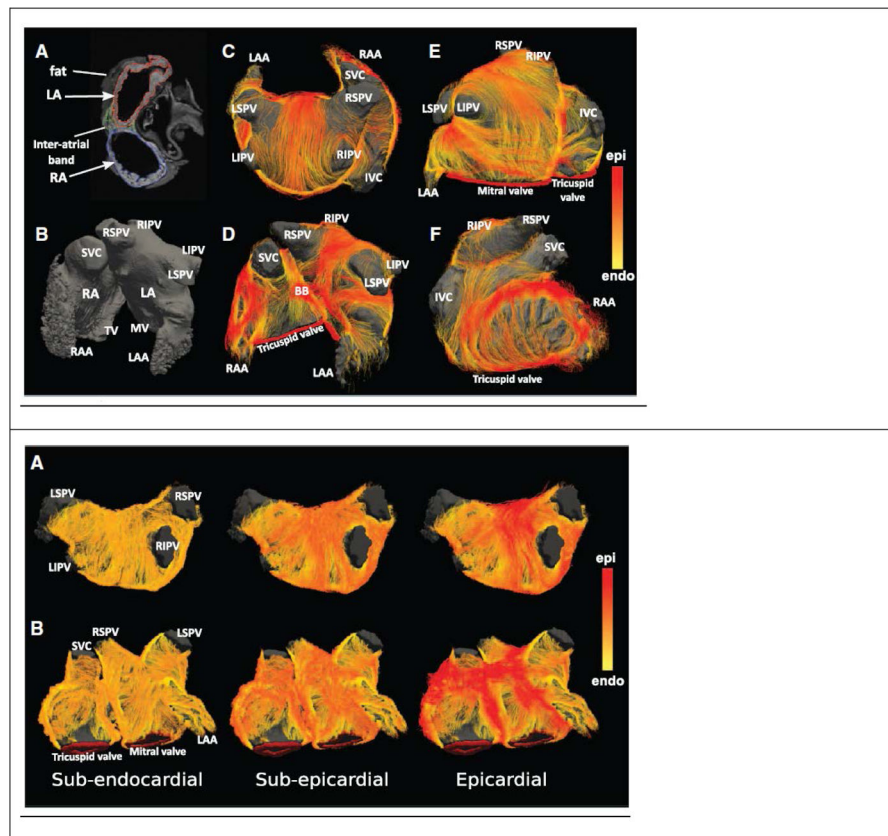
Fiber tractography of normal human atria, obtained from diffusion-weighted MRI imaging of ex-vivo samples. (Top) Atrial geometry. Left column (A, B) shows standard T1-weighted MRI images of the anatomy. Middle column (C, D) External surface view of the fiber tracts. Right column (E, F) anterior view of atrium. (Bottom) Changes in fiber tract orientation with depth in the left atrial wall of a single subject. Color code on right measures the similarity to the fiber tract direction on the epicardial surface. (After Pashakhanloo F et al., *Circulation Arrhythmia & Electrophysiology* 2016²⁵, with permission)
